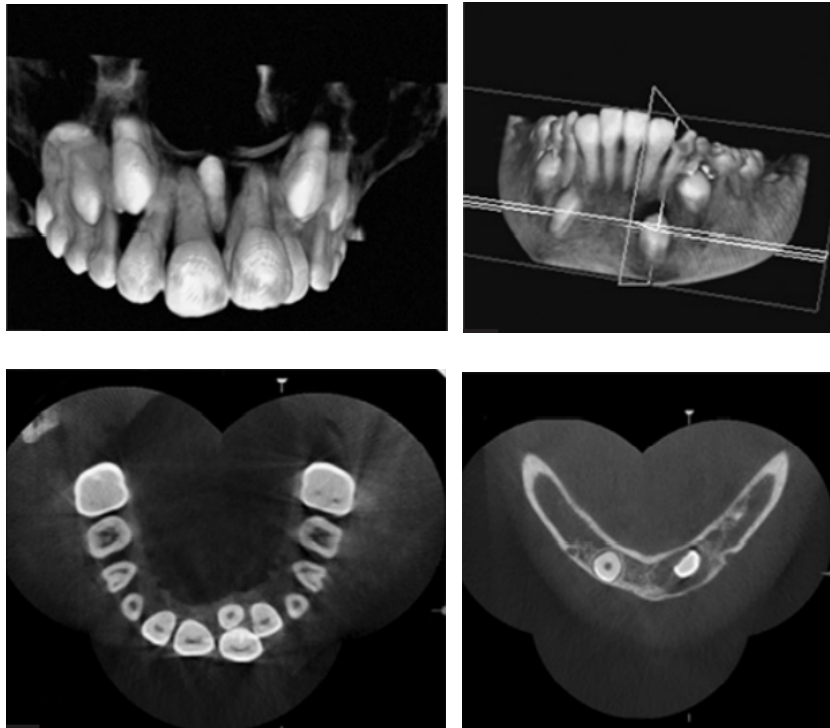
8 Cone beam computed tomography
